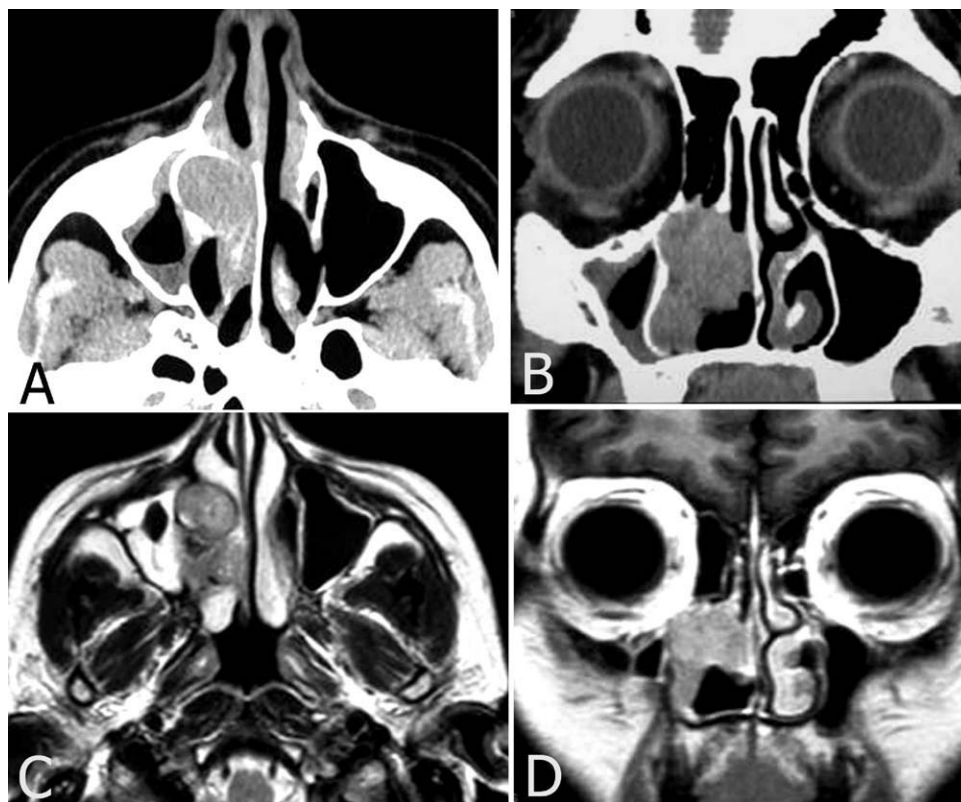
Plain CT on axial (A) and coronal (B) planes; MRI SE T2 on axial plane (C); MRI SE T1 after gadolinium administration on coronal plane (D). On the right side, the inferior meatus is partially occupied by a lesion arising from the most caudal part of the nasolacrimal duct. The duct itself is grossly enlarged; its bony walls are remodeled. Inferior growth along the lateral wall of the nasal cavity is observed, although the maxillary sinus is not involved.
